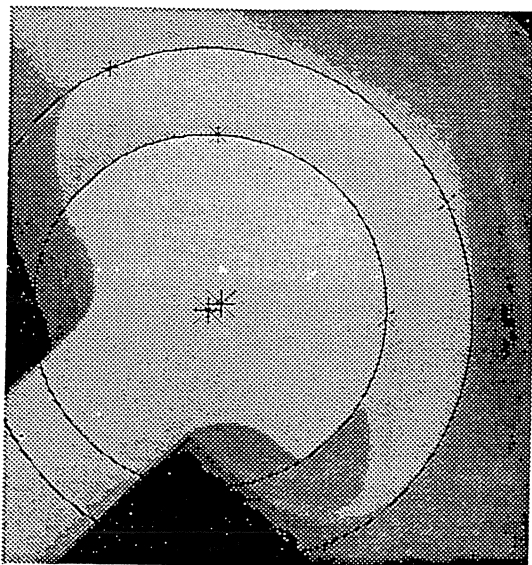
Digitized clinical radiograph with fitted ellipses
